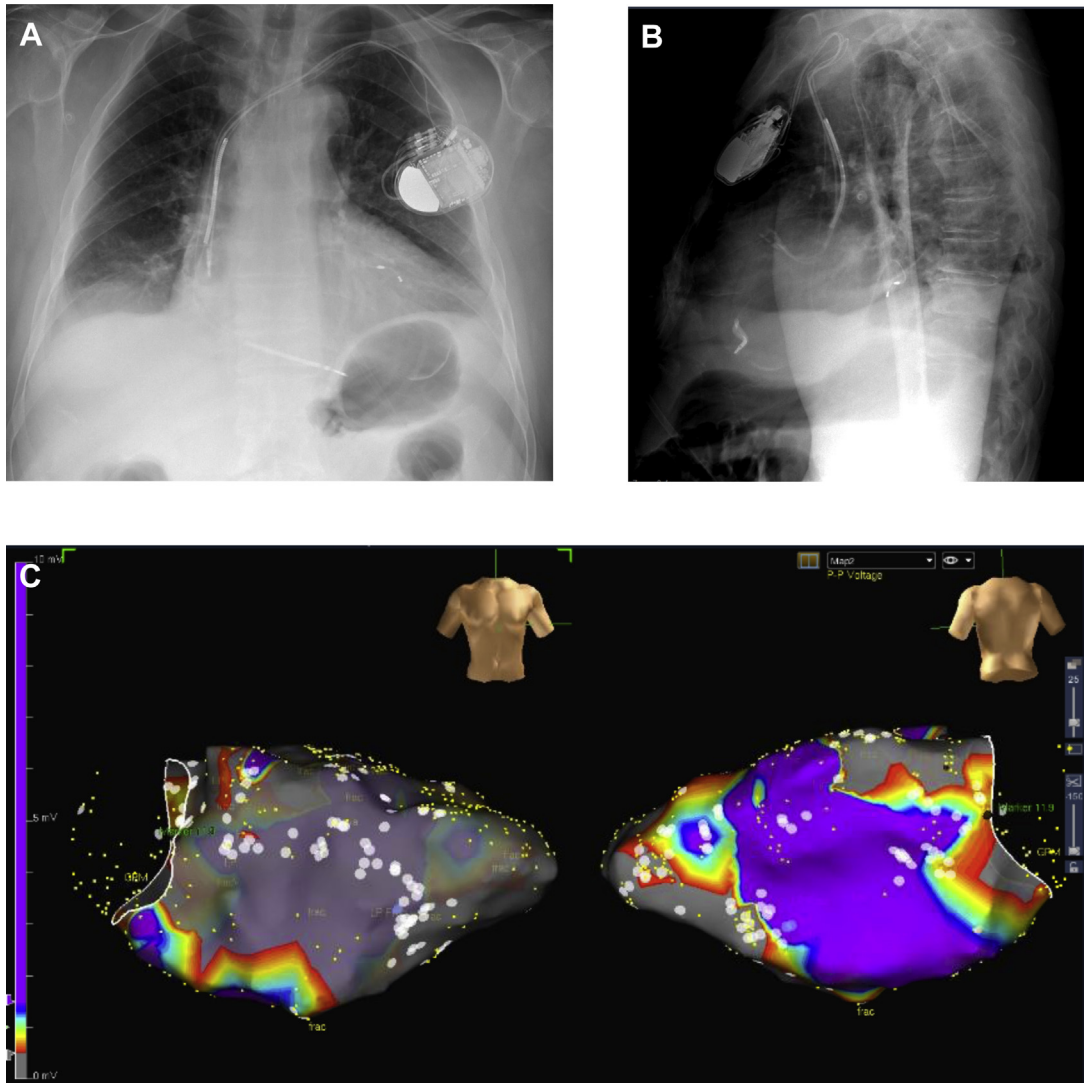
A: Posterior-anterior chest radiograph with cardiac resynchronization therapy device over left chest. B: Lateral chest radiograph with right ventricular lead visualized in the apex. C: Endocardial voltage map (Ensite, St. Jude, Minneapolis, MN) of the left ventricle at standard scar settings (0.5–1.5 mV) demonstrating very large septal anterior and apical scar with areas of preserved voltage in mid-inferior and mid-lateral walls (white dots = ablation lesions).
